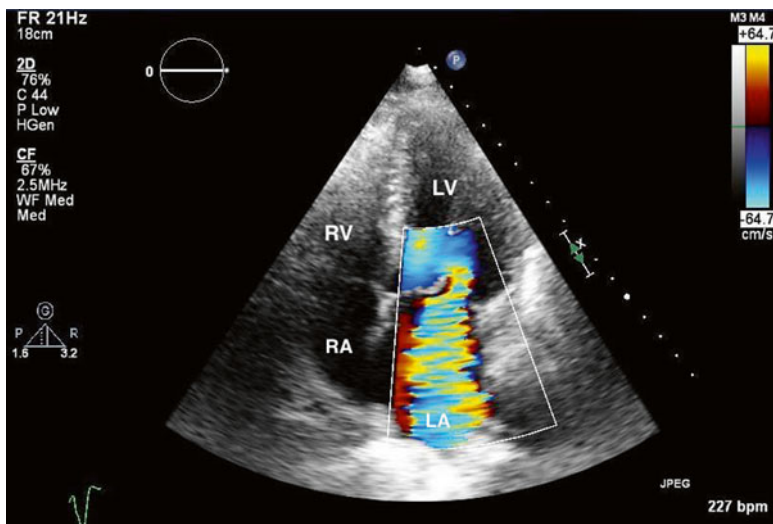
Apical four-chamber view with color Doppler over the mitral valve. Severe, posteriorly directed, mitral valve regurgitation. The left atrium (LA) is severely dilated. Left ventricle (LV). Right ventricle (RV). Right atrium (RA)
